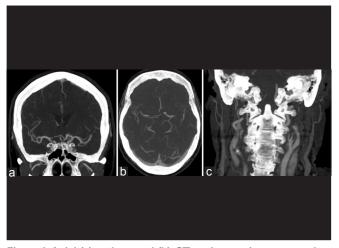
Axial (a) and coronal (b) CT angiogram images reveal an approximately 8-mm aneurysm along the junction of the left AI and ACoA. Significant stenosis of the extracranial ICA at its origin is also noted (c)
